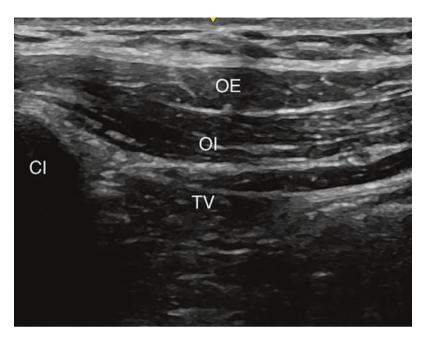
Ultrasonographic imaging from the anatomical landmarks and the targets: OE external obliques muscle, OI internal obliques muscle, TV transverse abdominal muscle
